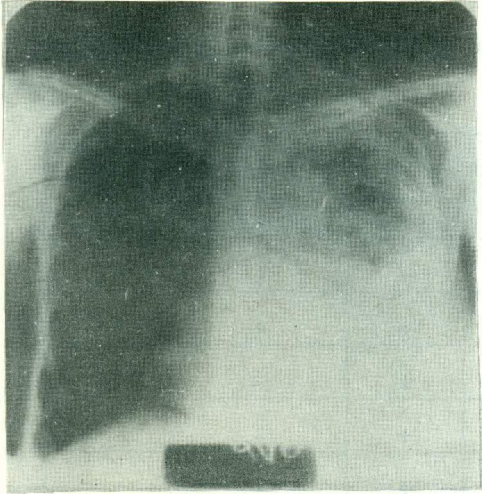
X-ray of a case with malignant pleural mesothelioma showing Lt. pleural effusion with nodular pleural thickening.
